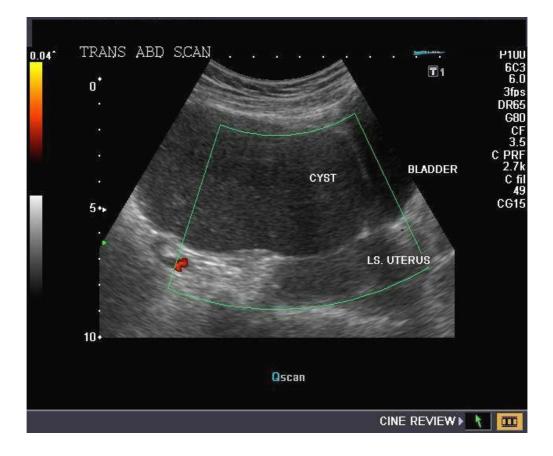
Sonographic images of endometrioma
